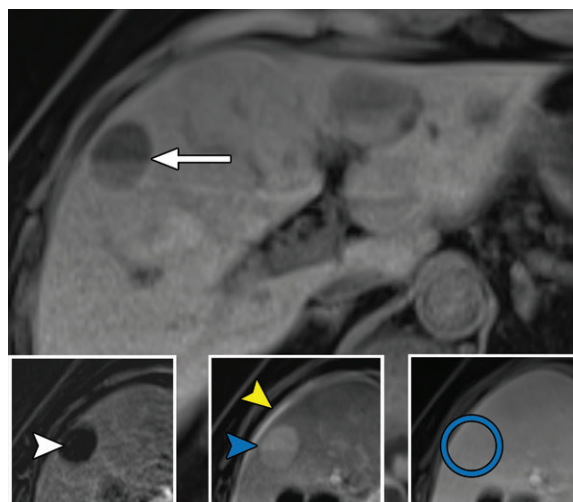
Subtraction misregistration artifact in a 79-year-old man with metastatic angiosarcoma. Axial precontrast T1-weighted MR image shows a fluid-fluid level within a hypointense liver lesion (arrow). Subtracted T1-weighted arterial phase MR image (left inset) shows no lesion enhancement (white arrowhead). Subtracted T1-weighted delayed phase MR image (middle inset) shows apparent enhancement (blue arrowhead), but when correlated with the source delayed phase image (right inset), this “enhancement” is due to through-plane misregistration from the patient taking a slightly different breath hold, resulting in normal parenchyma (blue circle) being subtracted by the lesion. In-plane misregistration is also evident with a hyperintense rim (yellow arrowhead) around the liver (middle inset) that is not present on the source image (bottom right inset).
